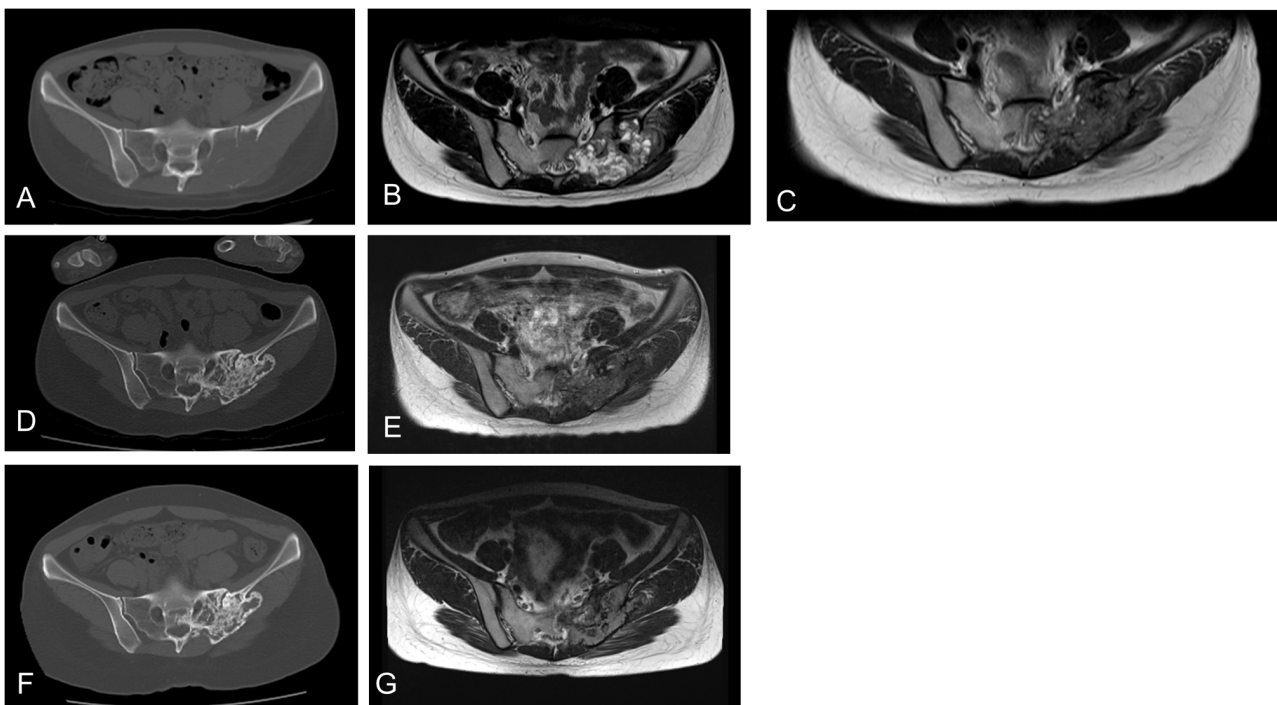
A 25-year-old woman with sacral GCTB. (A) A huge mass in the sacrum with cortical destruction and extensive soft tissue involvement was observed on CT. (B) MR imaging revealed a large tumor in the sacrum with high intensity in T2-weighted images. (C) Five months after the start of denosumab treatment, MR imaging showed remarkable shrinkage of the tumor. (D) Stable disease was observed over the next 2 years, with remarkable sclerosis of the lytic lesions. (E) The following 8-weekly treatment of denosumab for 6 months resulted in stable disease; hence, a 12-weekly denosumab treatment was provided. (F) At the last follow-up, the patient showed stable disease as shown in CT. (G) At the last follow-up, the patient showed stable disease as shown in MRI. GCTB, giant cell tumor of bone; CT, computed tomography; MR, magnetic resonance.
